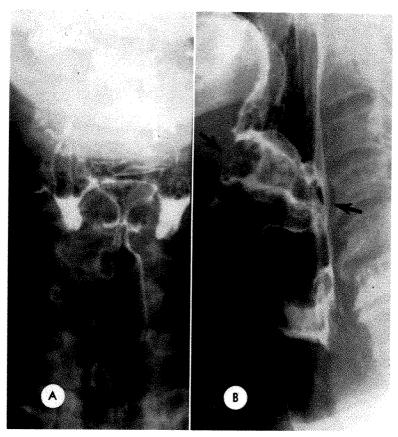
Case III. (A) Frontal and (B) lateral roentgenograms of positive contrast study. Exophytic tumor replacing epiglottis extends to fill the valleculae and along the pharyngeal surface of the epiglottis and proximal aryepiglottic folds (arrows).
